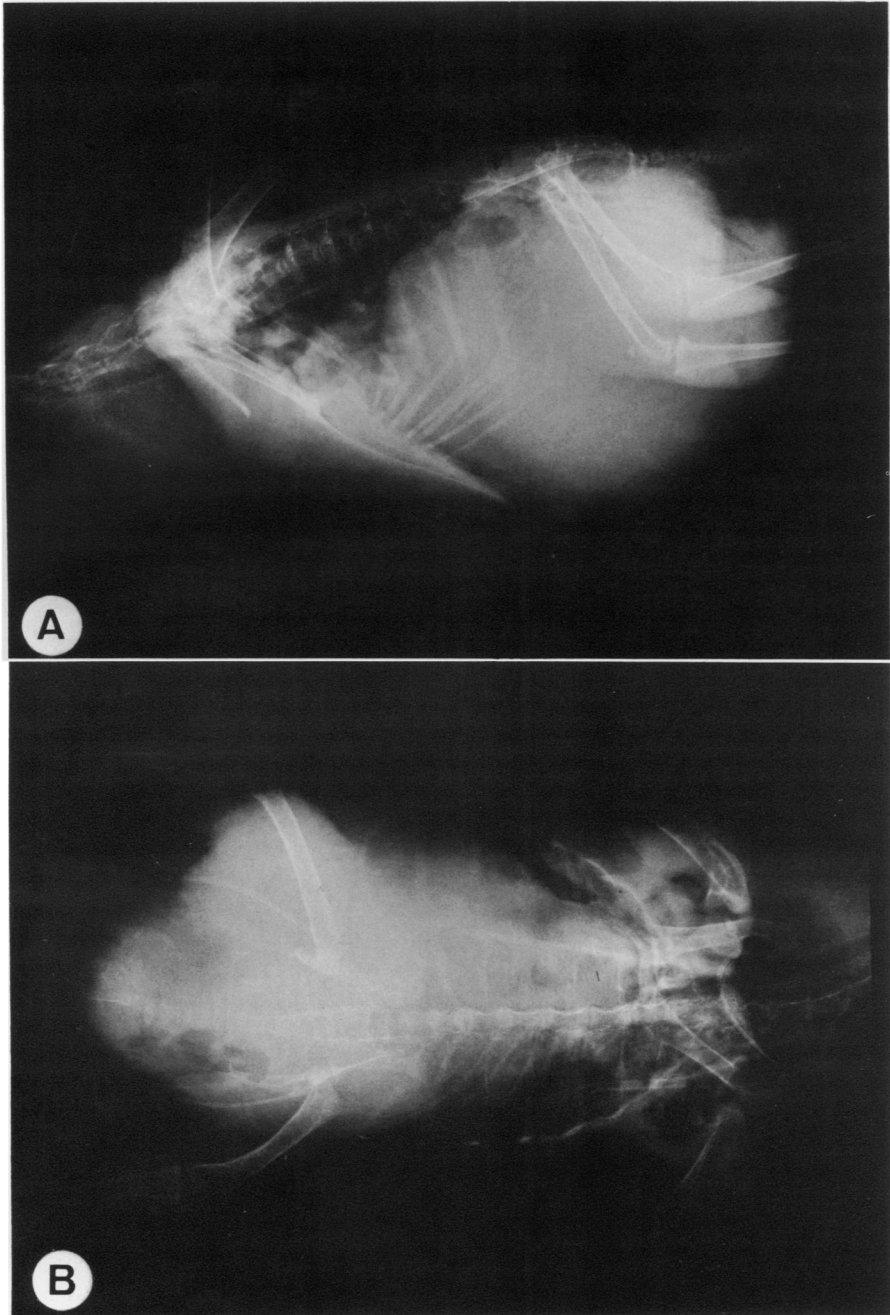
Lateral view (A) of an immature Congo African Grey Parrot with severe abdominal distension. Note the dorsally displaced gas-filled bowel loops. Ventro-dorsal radiograph (B) showing the lack of the normal "hour-glass" shape of the heart and abdominal organs.
